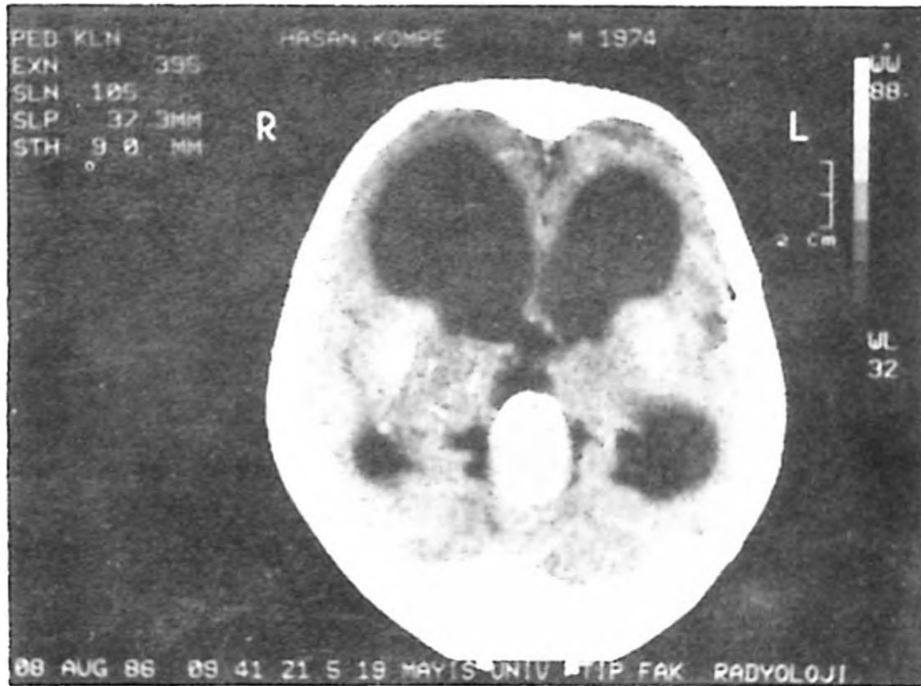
Precontrast CT study of Case No. 1 shows marked dilatation of the third and lateral ventricles with a disc-shaped lesion just below the third ventricle with punctate calcification on its sharply outlined surface.
